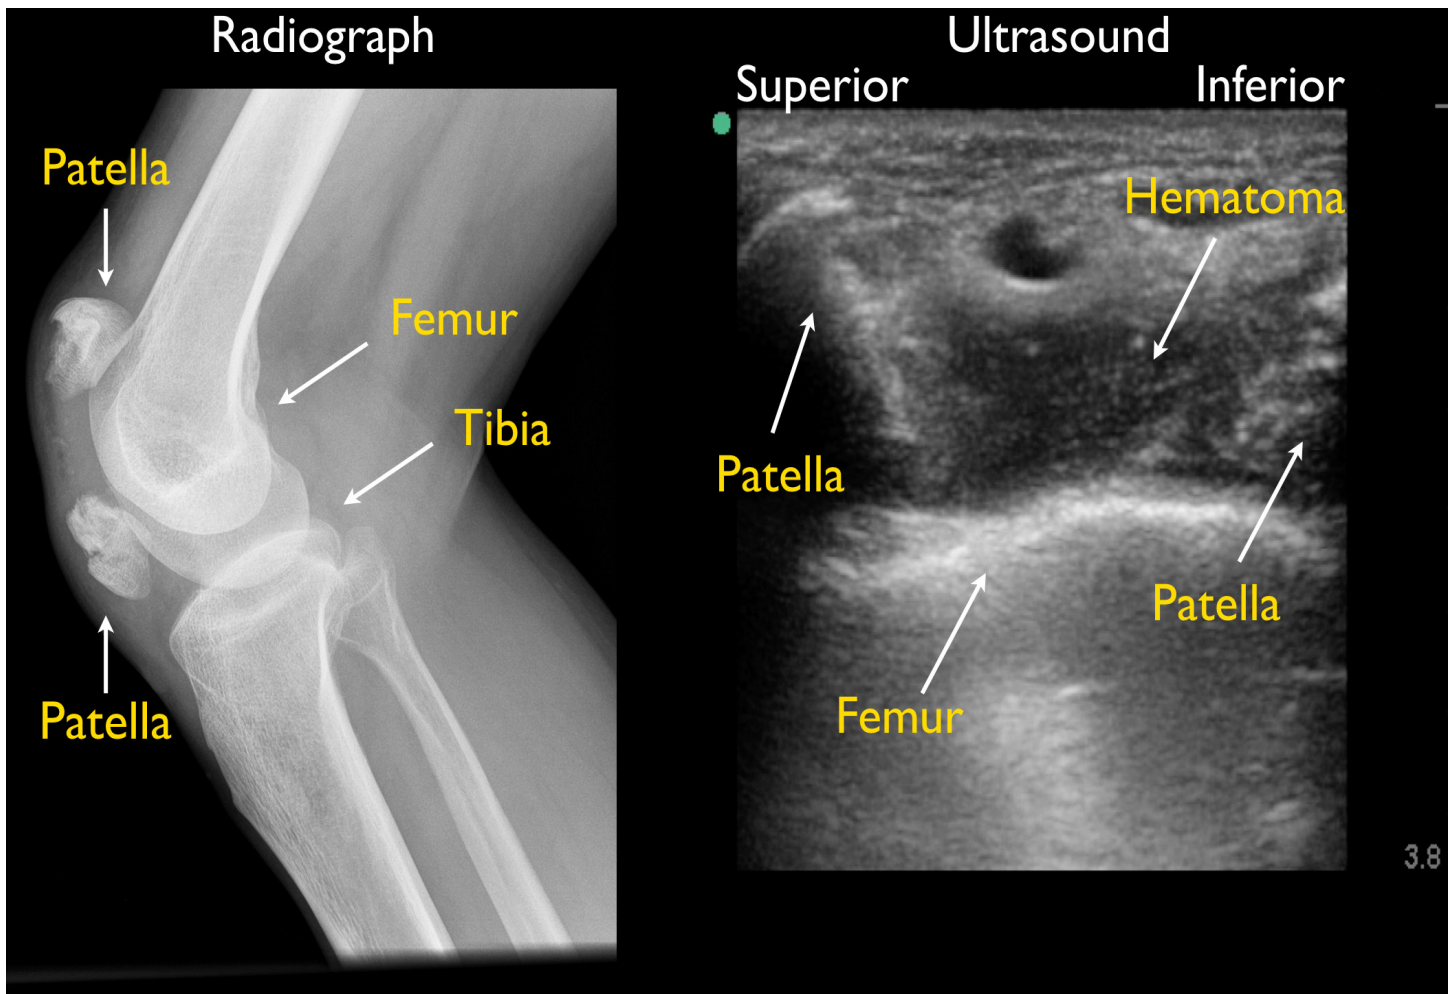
Patient's knee radiograph and ultrasound.
